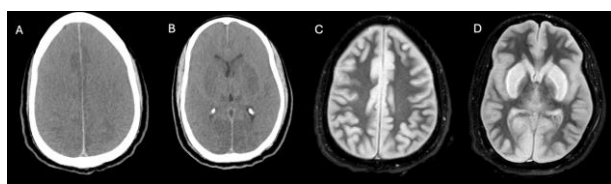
Hypoxic-ischemic encephalopathy imaging findings in the clinical setting of cardiac arrest. (A and B) Axial NECT demonstrates diffuse loss of gray-white matter differentiation with bilateral basal ganglia hypoattenuation, consistent with global hypoxic-ischemic injury. (C and D) Axial DWI sequences reveal extensive restricted diffusion involving both the cerebral cortex and deep gray matter structures, indicating acute cytotoxic edema characteristic of severe hypoxic-ischemic brain injury.
